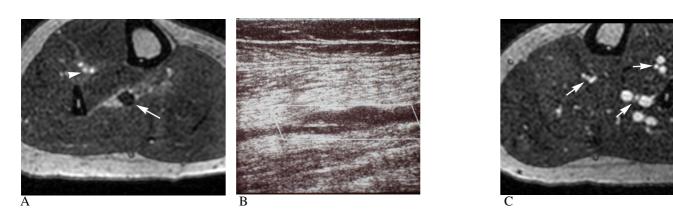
(A) Axial multiplanar reformat (MPR) of high resolution steady state images of the right lower leg in a 43-year old female patient referred for peripheral artery disease: Deep vein thrombosis in the fibular vein group (arrow), fibular and posterior tibial arteries are occluded, the anterior tibial artery (arrowhead) and veins show no disease. (B) Fibular vein thrombosis was confirmed by color duplex sonography. (C) In the left lower leg of the same patient all arteries (arrows) and veins present normally.
